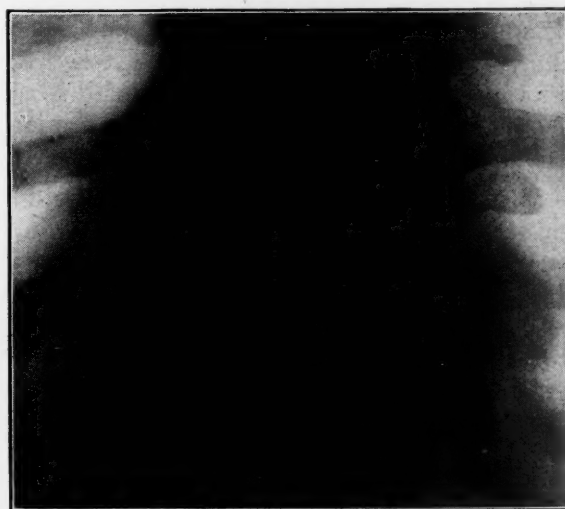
Radiograph showing the change in location of the pin.
